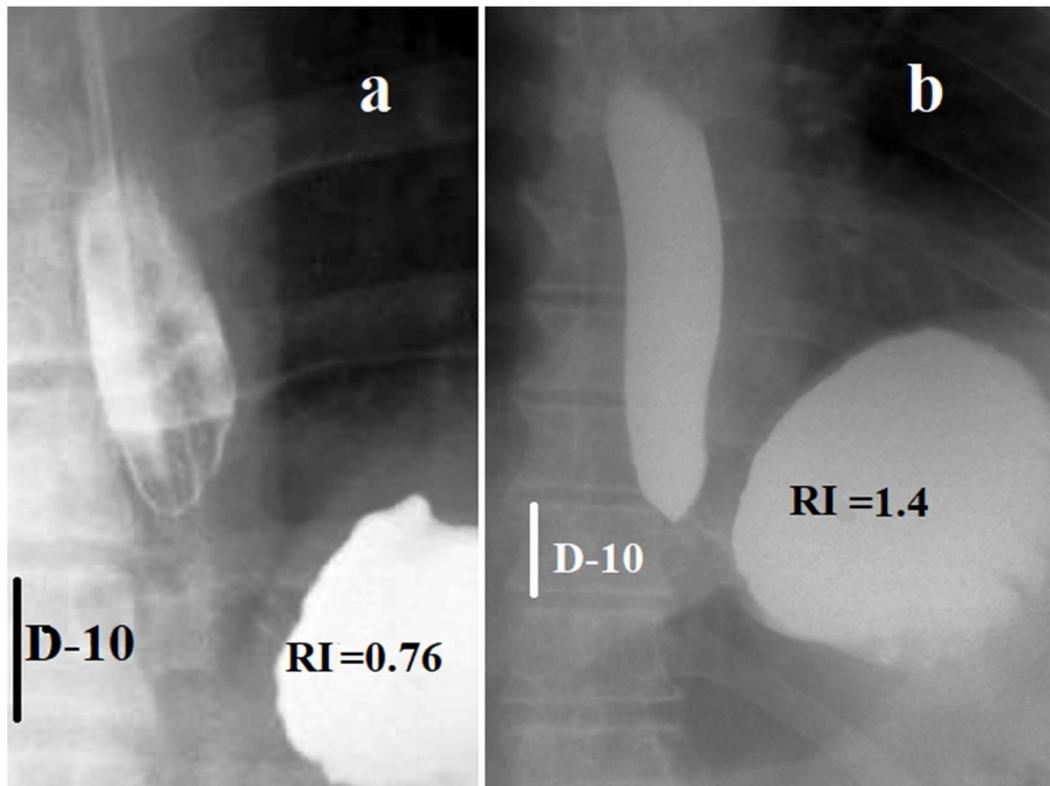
Radiographs of the EGJ in patients with GERD, performed with high pressure in the stomach. (a). Compression of the abdomen caused an increase in pressure in the stomach and resulted in a reflex contraction of the LES, which is defined as the distance between the barium in the esophagus and in the stomach. Although the esophagus is dilated relative to normal (1.0 versus 1.5 cm), and the length of the LES is shorter than the norm (2.5 versus 3.6 cm), the RI (reflux index is the ratio of the width of the esophagus to the length of the LES) is 0.76, which indicates a mild form of GERD. (b). Increased pressure in the stomach when lifting straight legs. The width of the esophagus is 2.5 cm, and the length of the LES is 1.9 cm. RI = 1.4. A higher RI indicates a more severe GERD.
